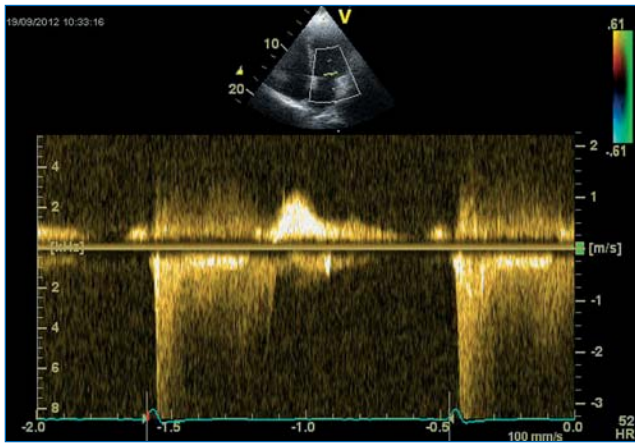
CW Doppler. Soft density, parabolic MR jet.
